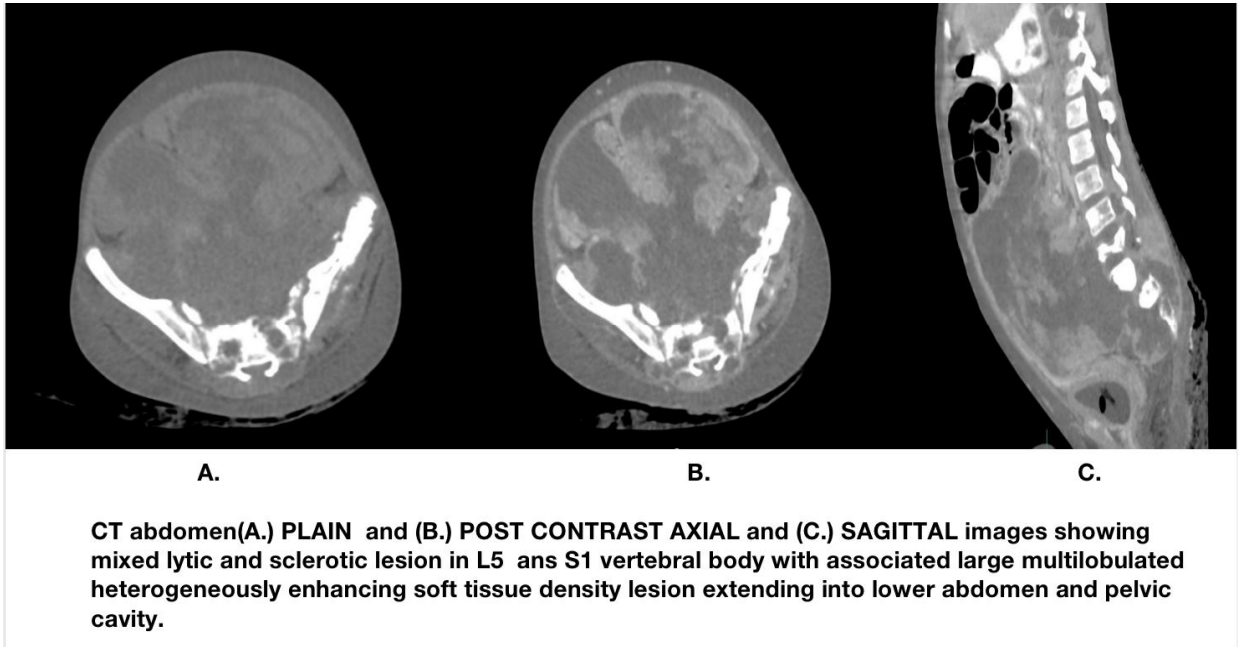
CT abdomen(A.) PLAIN and (B.) POST CONTRAST AXIAL and (c.) SAGITTAL images showing mixed lytic and sclerotic lesion in L5 and S1 vertebral body with associated large multilobulated heterogeneously enhancing soft tissue density lesion extending into lower abdomen and pelvic cavity.
